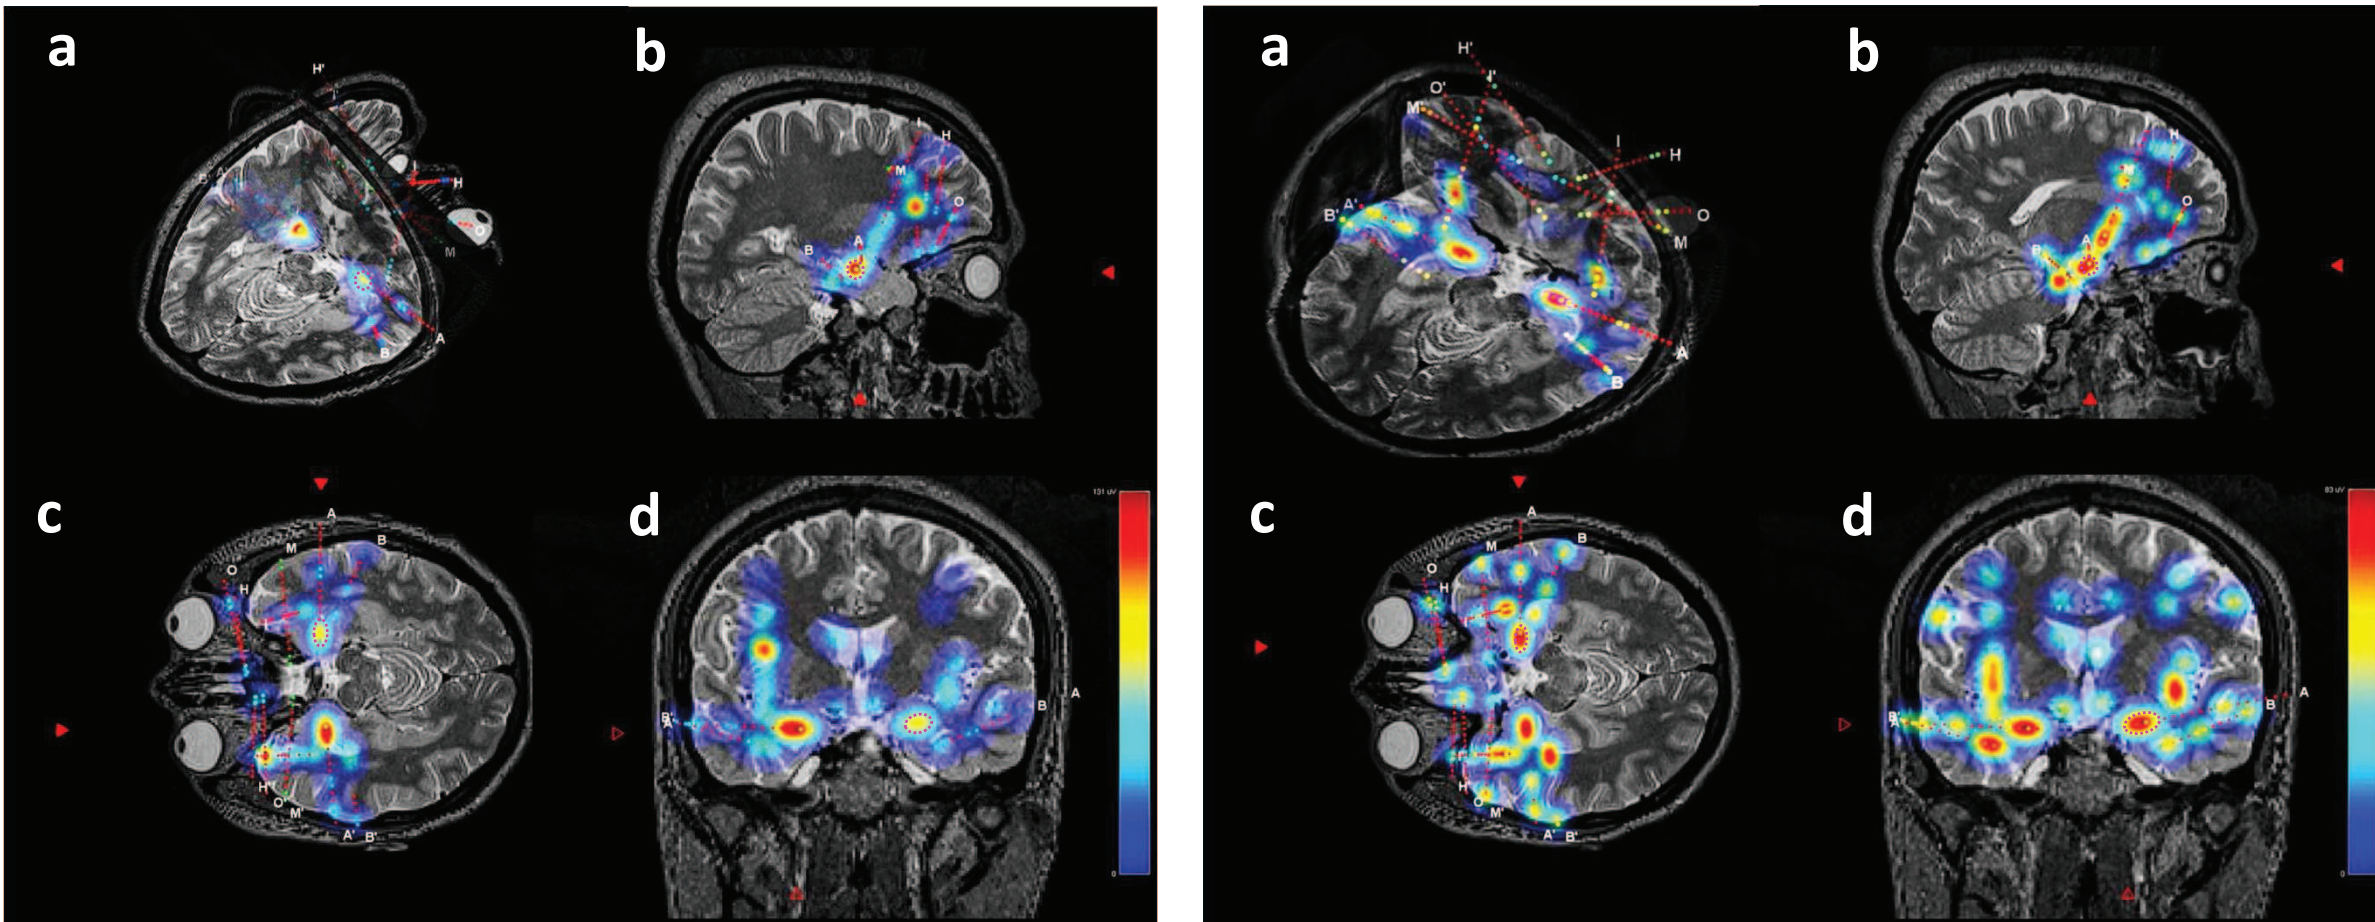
3D outbound activation maps for patient 10, expressed as the mean amplitude of responses on all contacts, for each stimulation location. a) 3-D view of the maps, blended with MRI scans; b,c,d) MIP projections of the activation on sagittal, axial and coronal MRI views. SOZ contacts are marked using magenta circles.
